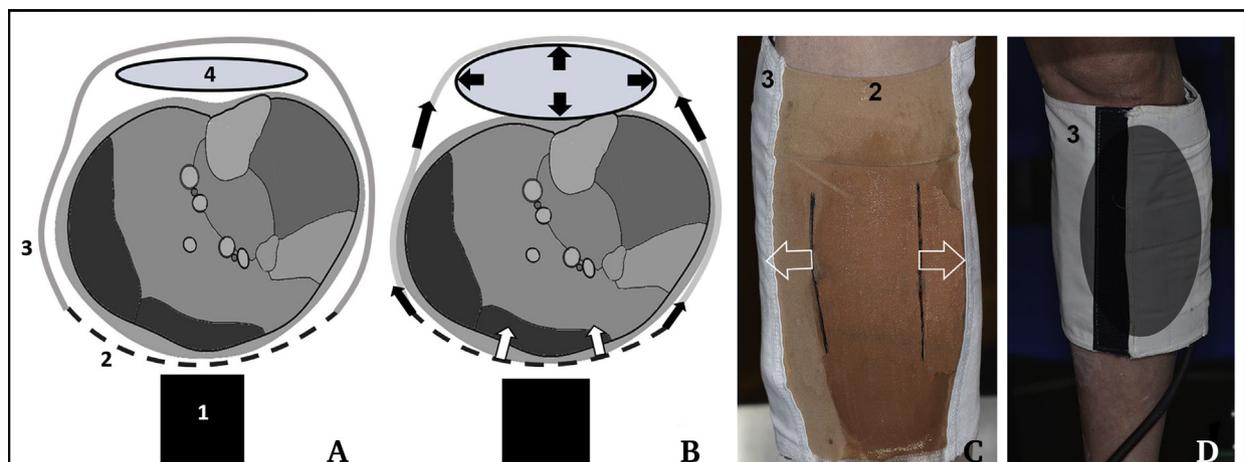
Hybrid cuff-knitted fabric device used in the trial. (A) device with deflated cuff. 1, ultrasound probe; 2, knitted fabric (dotted line); 3, rigid wrapping which is sewn to the knitted fabric; 4, inflatable cuff. (B) device with inflated cuff and resulting forces. (C) the posterior aspect of the device; the arrows indicate the displacement of the vertical black lines when the cuff is inflated and the knitted fabric stretched. (D) anterior aspect, the oval grey transparent zone represents the location of the air pressure cuff underneath the rigid wrapping.
